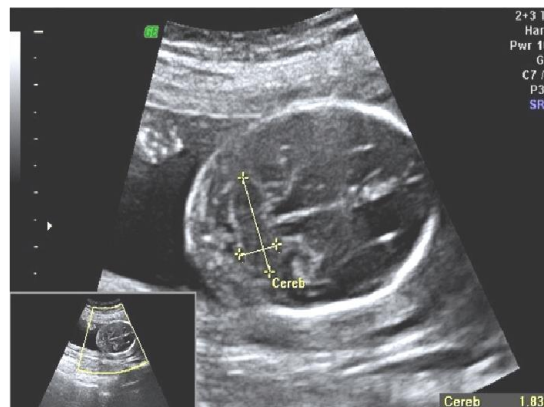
36): Shows ultrasound image with linear measurement
